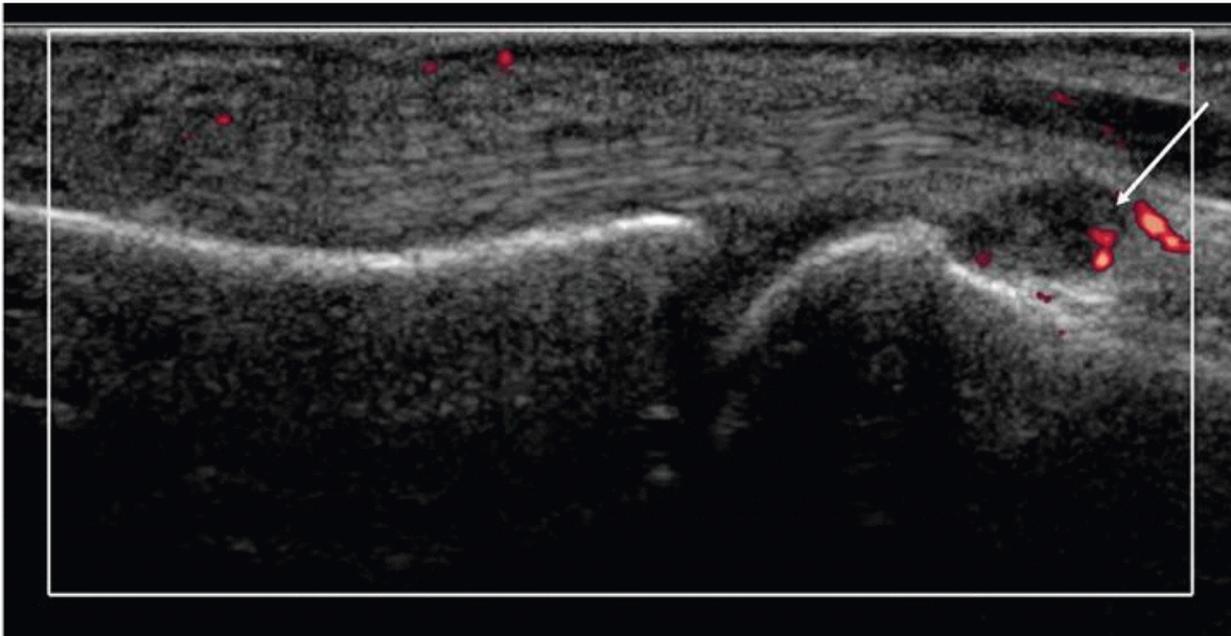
Power Doppler longitudinal scan of volar aspect of the fifth metacarpophalangeal joint. The proximal recess is distended and contains echogenic synovium and neovascularity in keeping with synovitis.
